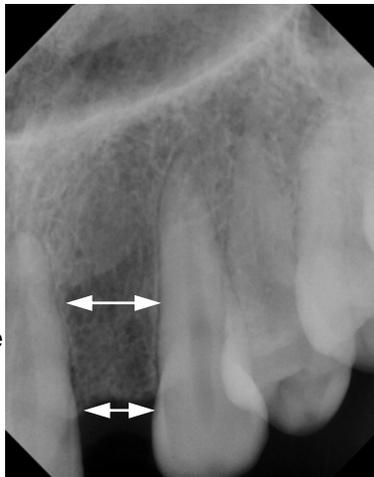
B: Interdental space has to be evaluated radiographically before the placement of dental implants
